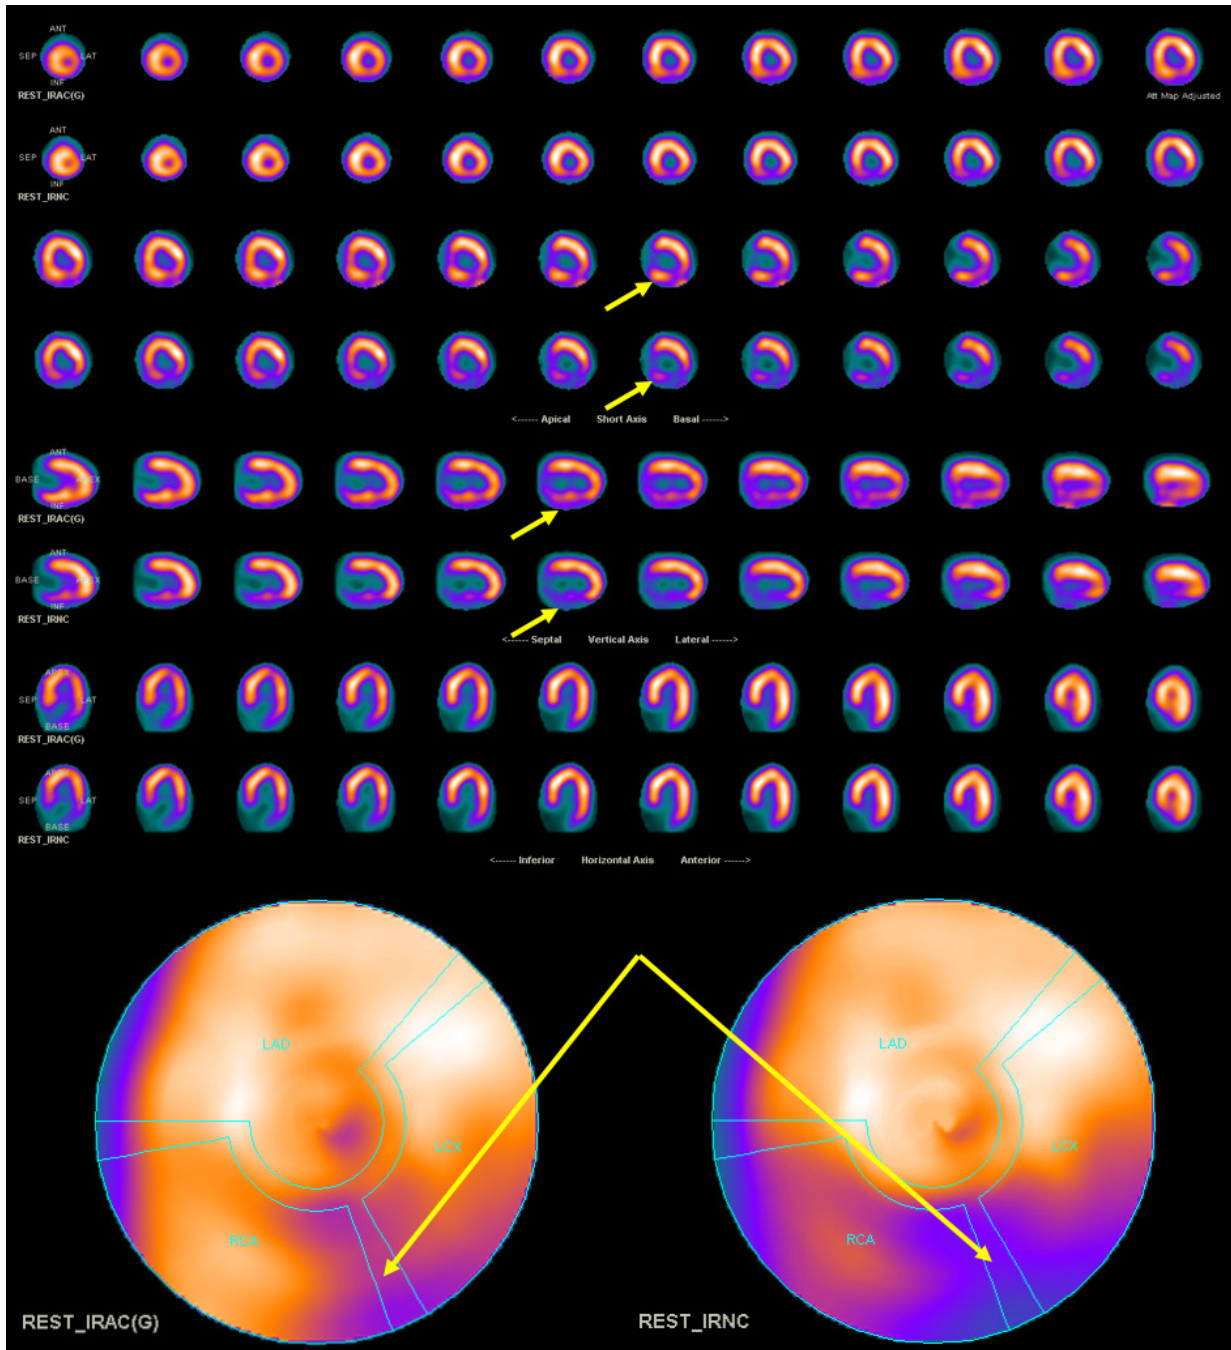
Cardiac SPECT/CT study with upper slice of each pair of slices showing CTAC data, while the lower slice of each pair represents data with no AC applied. At the bottom, AC (left) and NAC data (right) are shown as bullseye plots. The yellow arrows indicate AC recovering attenuated counts (left) and diminished in the NAC data (right).
